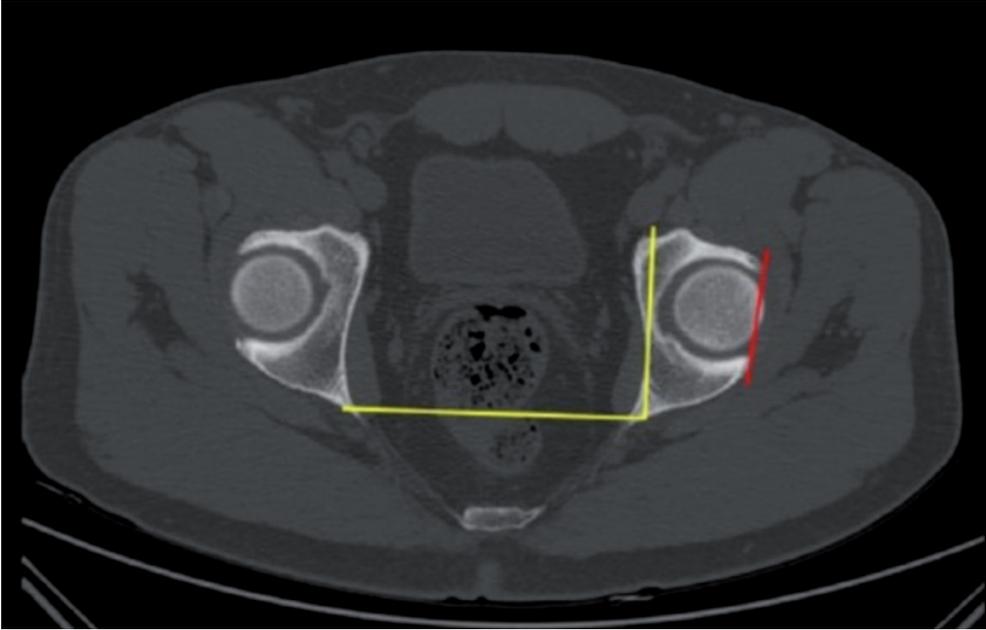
Anteversion of the acetabulum is measured on a CT-scan in the axial plane (reprint with permission [20])
